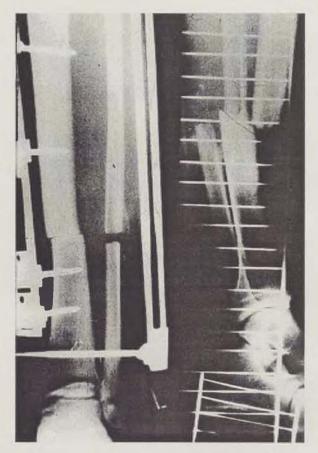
Radiographs before and after by the external fixation.
